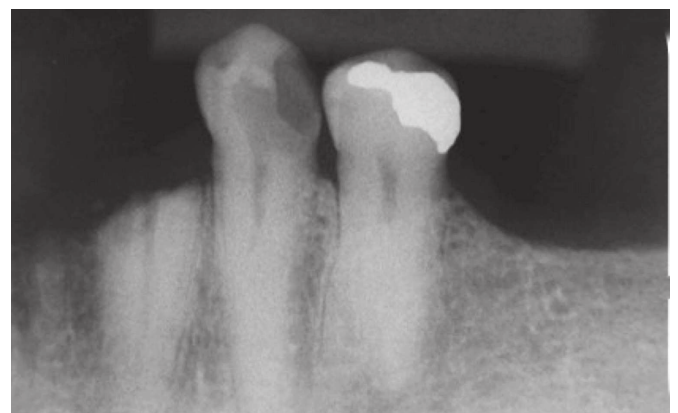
Initial radiograph. Tooth #34 evincing severe caries with root canal light visible only at the cervical third.
